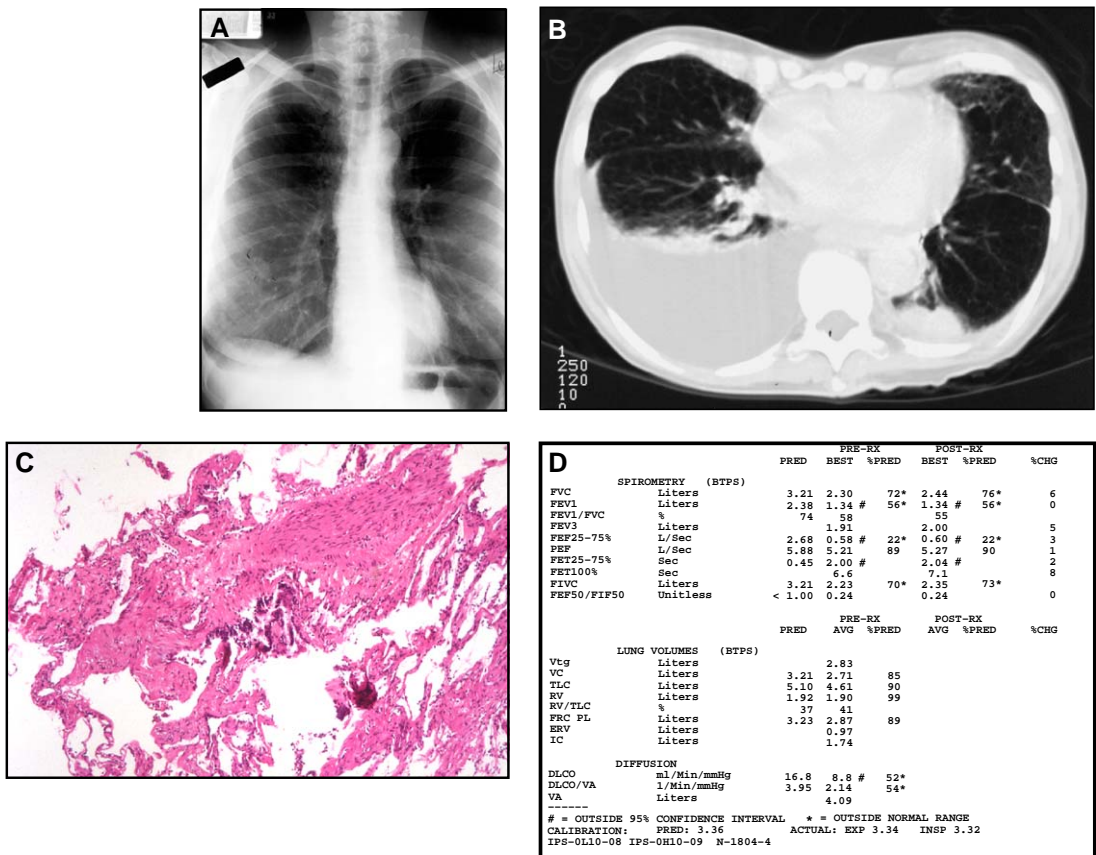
A 62-year-old woman who has had dyspnea for 5 years. At the time of her hysterectomy at age 48 years, the chest radiograph was read as suggestive of hyperinflation. She had been treated with estrogen replacement therapy since age 49 years. She developed (A) persistent chylous effusion and at age 60, a wire was placed in the thoracic duct for management of the effusion. A lung biopsy was performed demonstrating LAM. No angiomyolipomas or meningiomas were detected on CT scans of the abdomen or brain, respectively. (A) Posterior-anterior chest radiograph: hyperinflated lung at the time of the hysterectomy. (B) CT scan of chest demonstrating large right pleural effusion. (C) Cellular infiltrates diagnostic of LAM in section from video-assisted thoroscopic biopsy. (D) Pulmonary function tests with severe obstructive changes not responsive to bronchodilators and decreased diffusion capacity. Arterial blood gas on room air and at rest (7.43/PCO₂ 42/PO₂ 52/87%) demonstrates significant hypoxemia.
